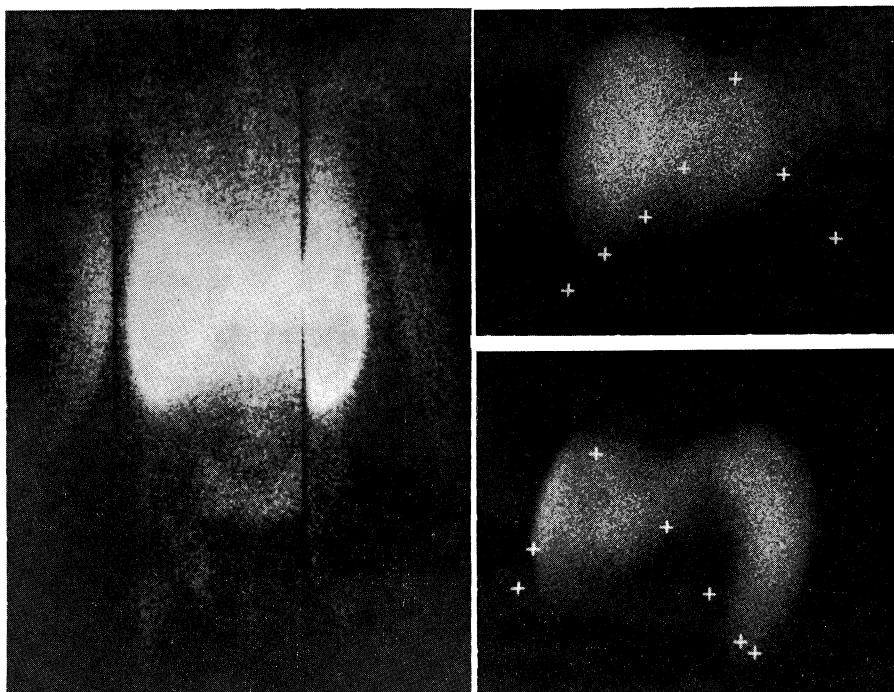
^{99m}Tc myeloscintigram. *Left* :...whole body.
